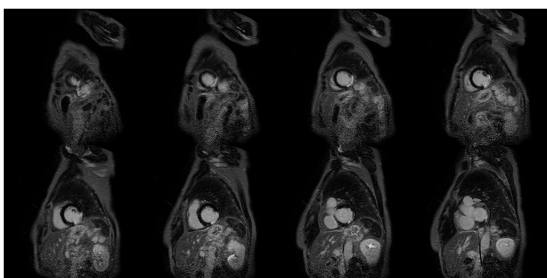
Consecutive MRI slices of an example patient with myocardial scar.
